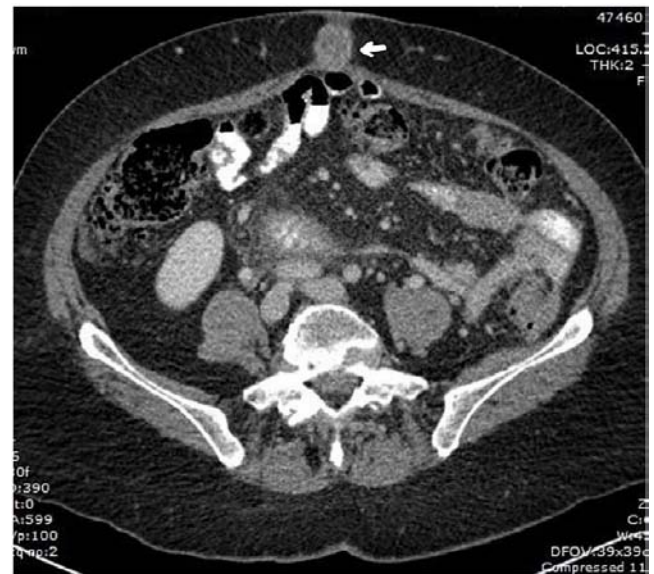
CT scan showing umbilical lesion (SMJN). Source: Dharan M, Ryan-Fisher C. Sister Mary Joseph Nodule and Concomitant Pancreatitis as Initial Presentation of Pancreatic Adenocarcinoma – Case Report and Review of the Literature. *Cureus* 13(12): e20069. doi:10.7759/cureus.20069
